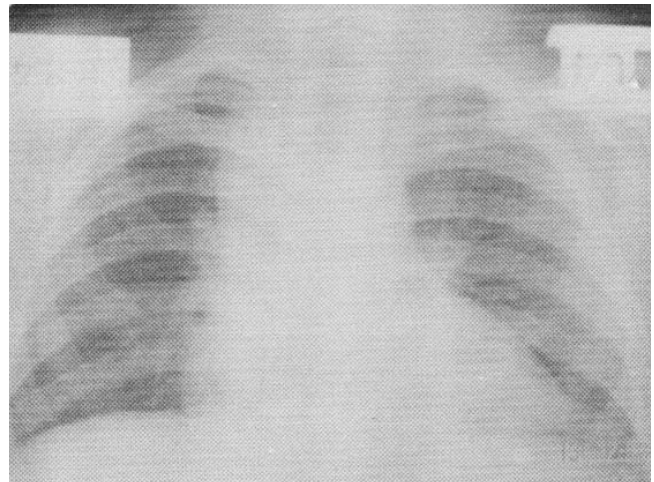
Chest radiograph showing widening of superior mediastinum.
